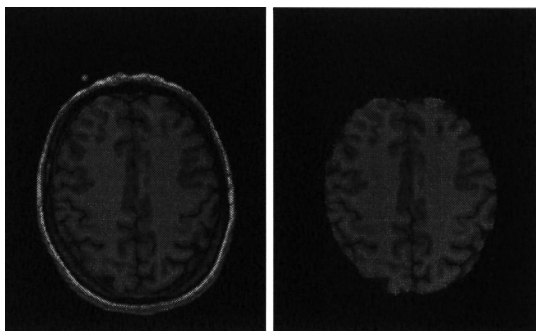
An MRI slice and the result of the morphological segmentation of the brain. The thresholds  $s_{\text{inf}} = 20$  and  $s_{\text{sup}} = 125$  have been used.
